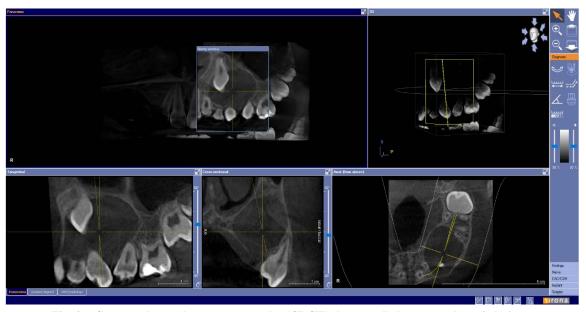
Computed cone-beam tomography (CBCT) shows well-demarcated cystic lesions.
